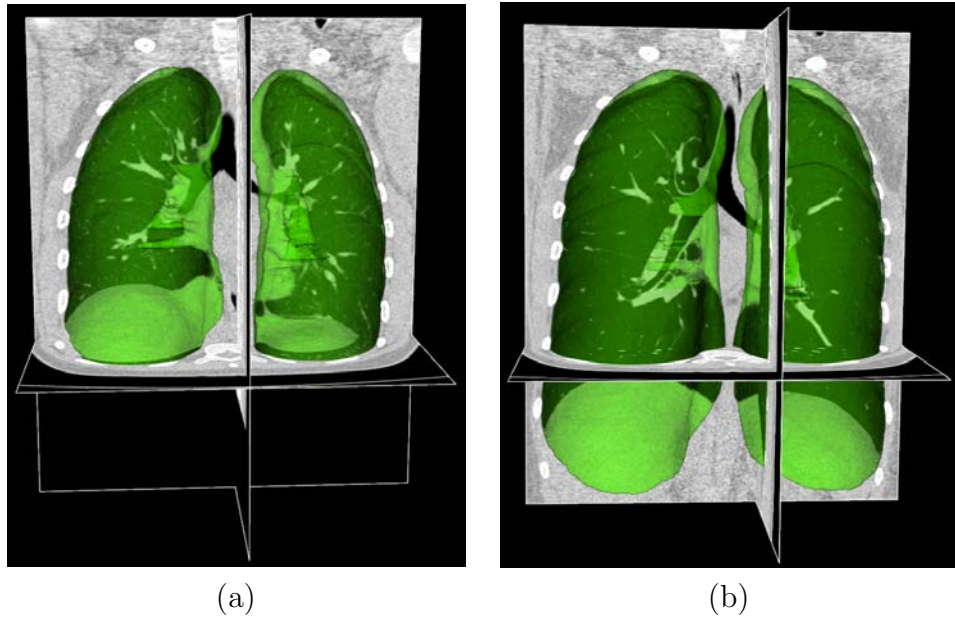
Rendering of lung CT images acquired at (a) FRC and (b) TLC.
